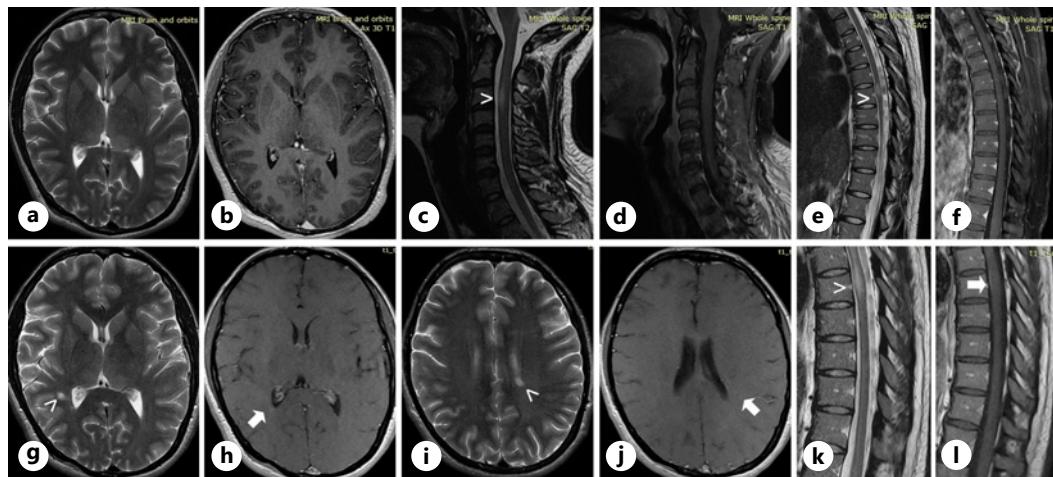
Representative images from initial (a–f) and repeat (g–l) MRI studies of the brain and spinal cord. a–f Images of initial MRI studies including axial T2-weighted (a) and T1 with gadolinium (b) from the brain at the level of the internal capsule; sagittal T2 images of the cervical spinal cord (c) showing the high signal lesion at C3 level (open arrowhead) which was not enhancing in T1 with contrast (d); and thoracic spinal cord T2 (e) and T1 with contrast (f) images showing a non-enhancing lesion at T6-7 level (open arrowhead). g–l In the repeat MRI study 2 years after diagnosis and treatment with IFN-beta-1 α , axial images of the brain demonstrate new periventricular lesions (arrowheads) in T2 images (g and i) with subtle contrast enhancement (arrows) in corresponding T1 images with contrast (h and j). Furthermore, thoracic spinal cord images (k, l) show enlargement and subtle contrast enhancement of the T6-7 spinal cord lesion (T2 image in k and T1 with contrast in l).
